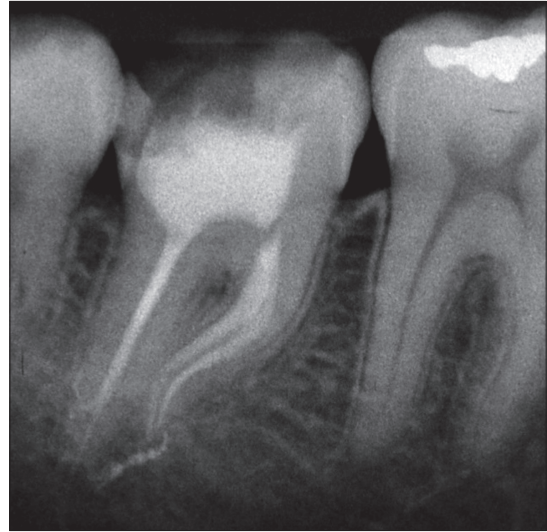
Periapical radiograph of tooth #47 after 6 months, revealing no presence of failure in root canal filling or periapical lesions.
